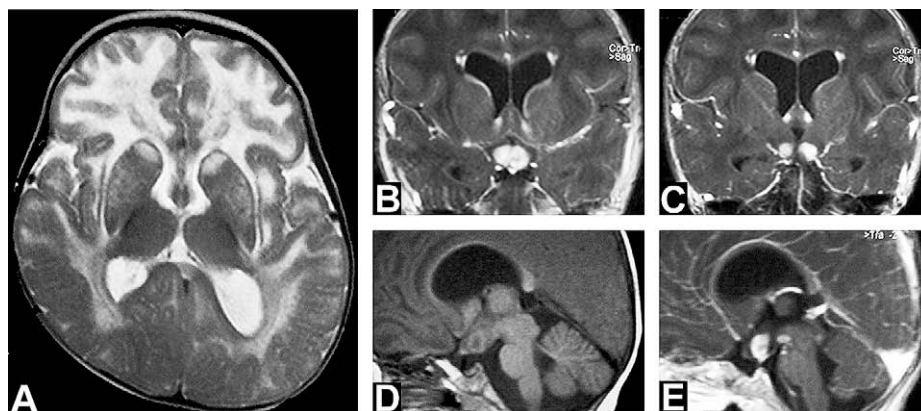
The MRI at 14 months old showing typical features of infantile AXD: the T2-weighted image shows severe white matter abnormalities with frontal predominance and basal ganglia involvement (A), associated with enhancement of the ventricular lining following gadolinium infusion (B and C). In addition, an important enlargement of the optic chiasm with a heterogeneous signal on T1-weighted image (D) with massive enhancement (B, C, and E) is present.
